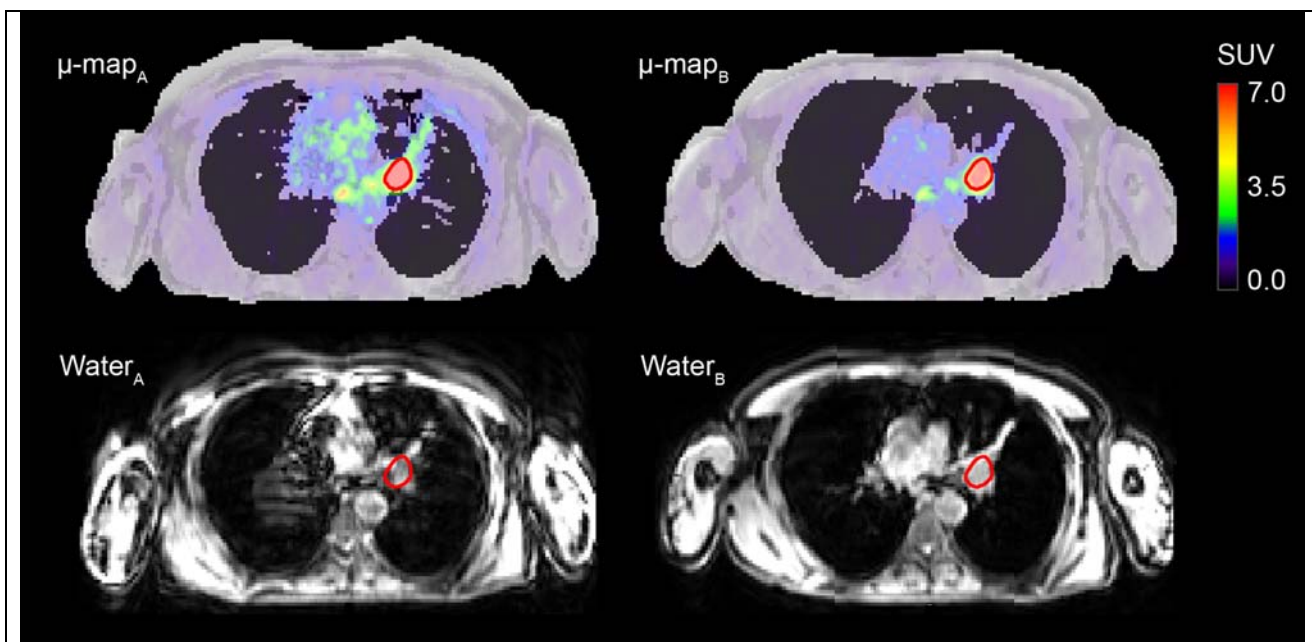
Patient 7, examination 1. Intra-subject repeated MR-AC maps ( $\mu\text{-map}_A$  and  $\mu\text{-map}_B$ ) fused with  $\text{PET}_A$  and  $\text{PET}_B$ , along with their respective Dixon water images. A  $\Delta\%SUV_{\max}$  of -29% is found in the tumor delineated in red. Respiratory motion artifacts cause erroneous tissue classification in  $\mu\text{-map}_A$ .
